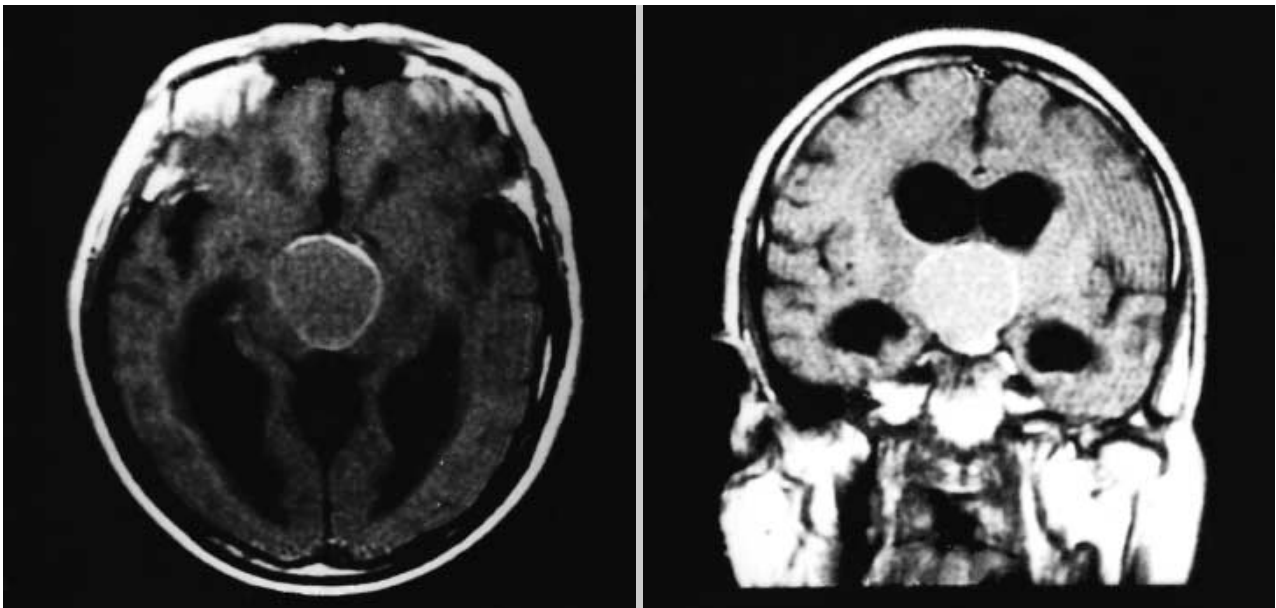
Preoperative brain MRI in a 65-yr-old female who presented with general weakness and hemianopsia (Patient No. 6).
